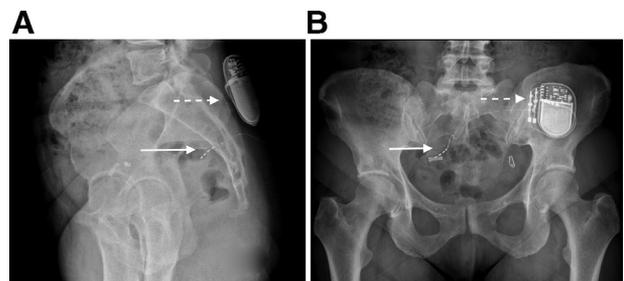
Sacral nerve modulation (SNM) on X-rays: Anteroposterior (A) and lateral (B) views of the lead through S3 sacral foramen and the implanted programmable stimulator.
